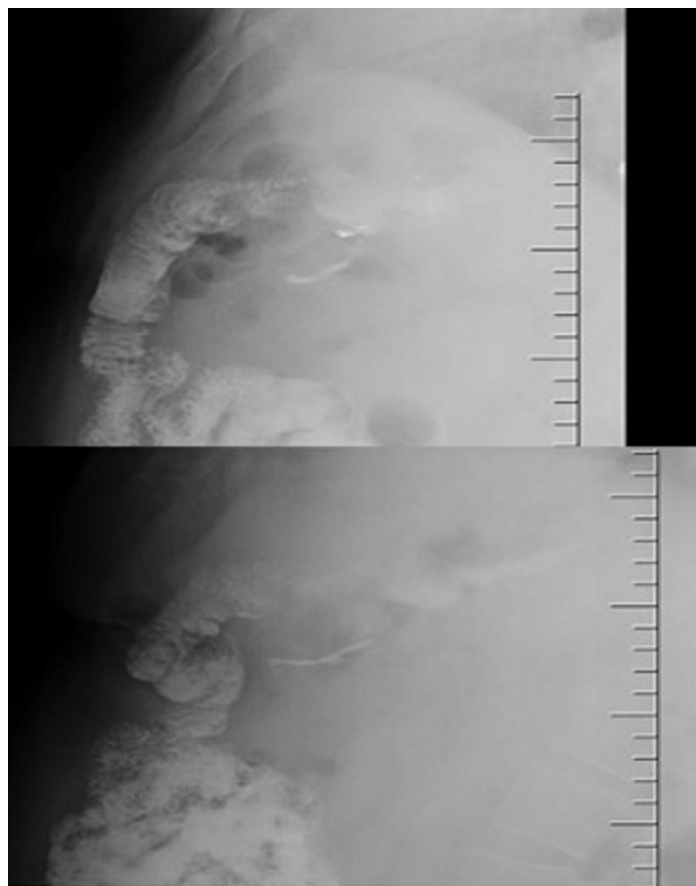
Contrast radiography. Only a very small amount of barium passes through the gastro-gastric outlet whereas nearly all passes through the gastro-jejunal anastomosis.
